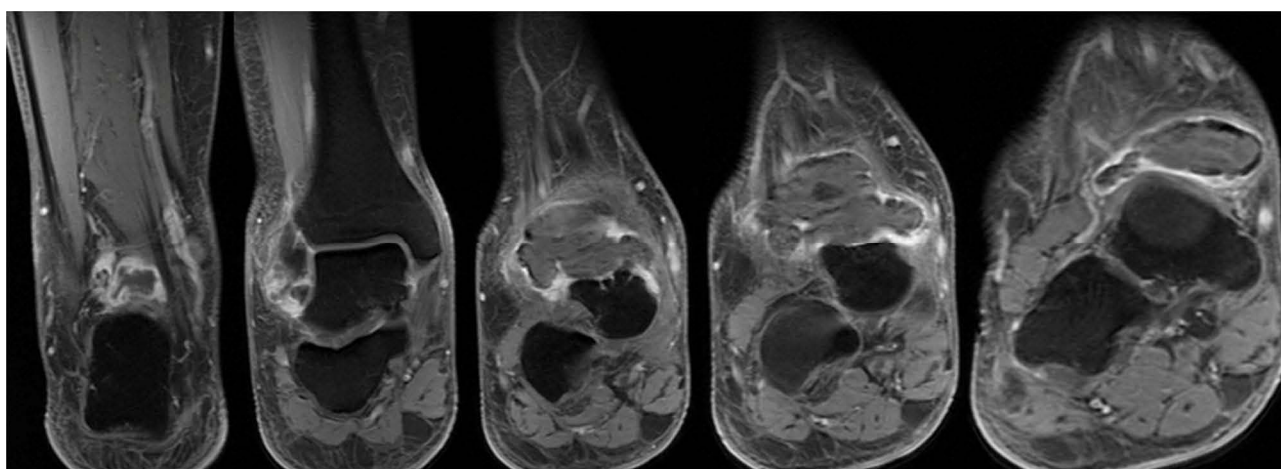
Coronal MRI T2 of the right ankle showing anterior calcified loose bodies.
